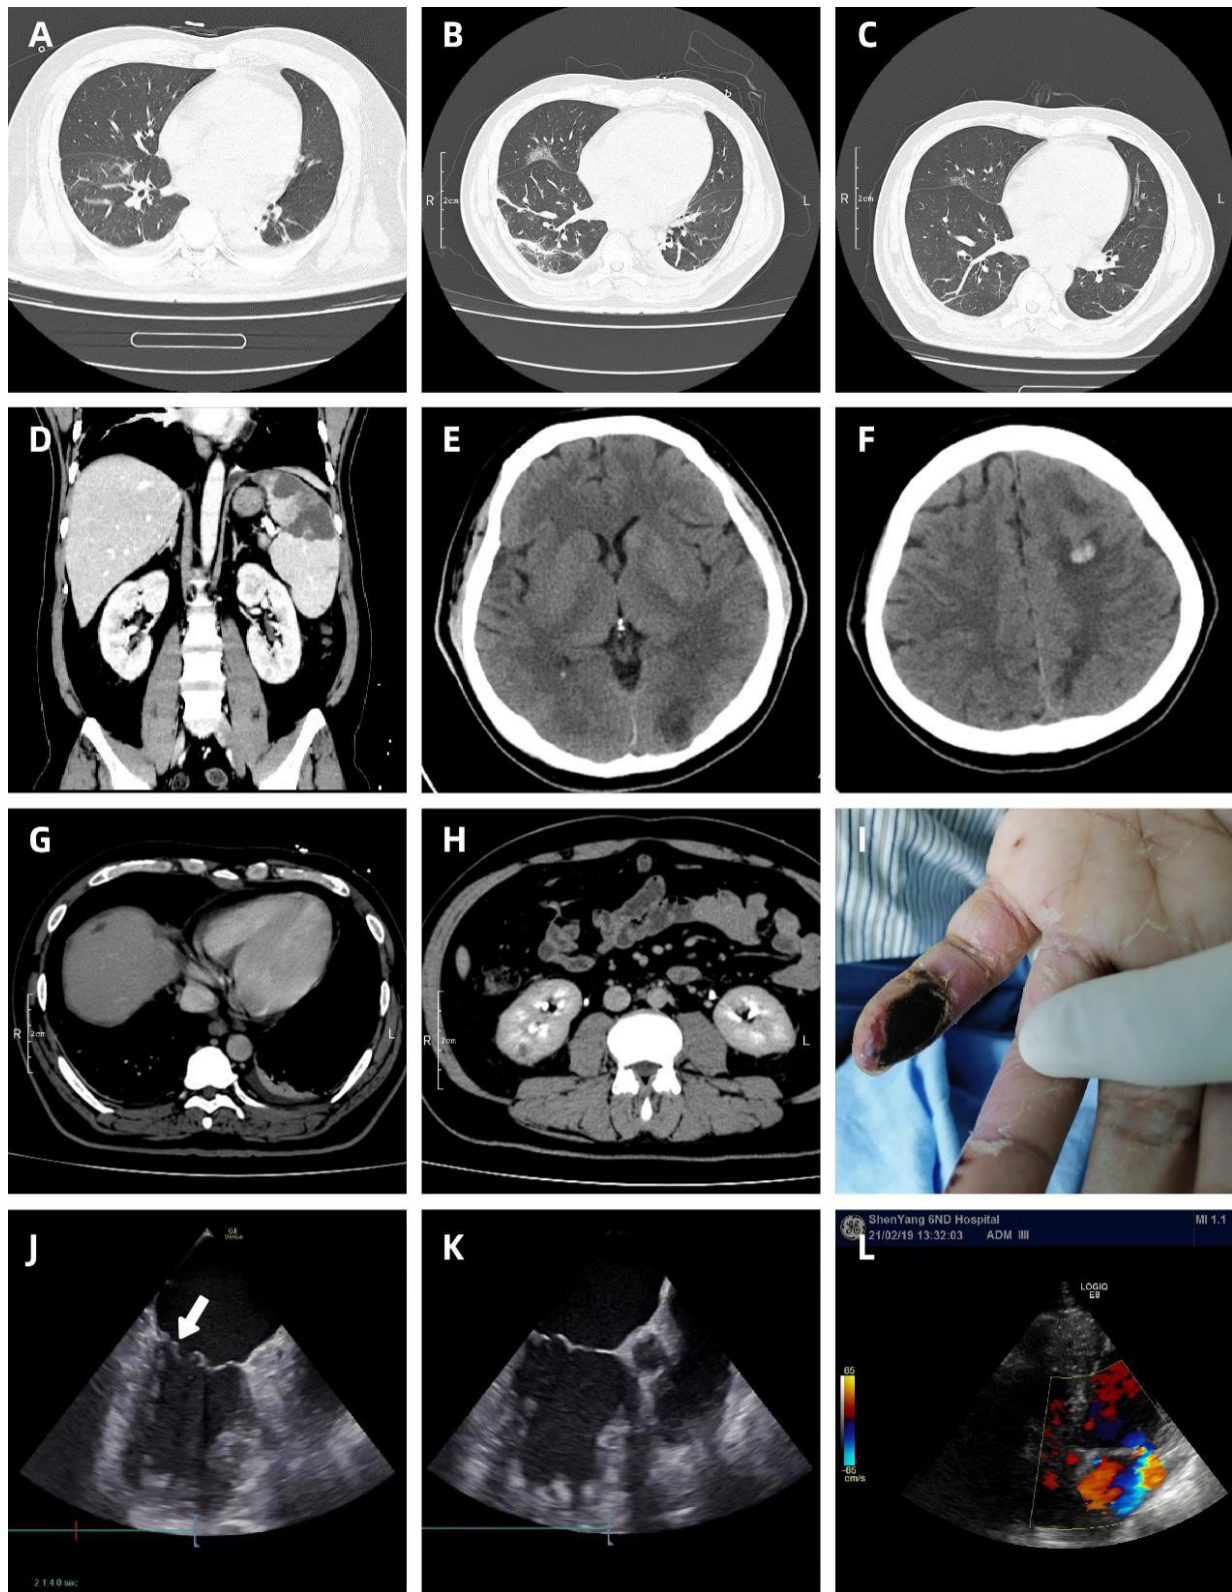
CT image. (A,B,C) The ground glass opacity of both lungs increased from a small amount to a patchy one with thickened blood vessels, and then to the inflammatory lesions. (D) Multiple splenic infarcts with the maximum diameter of 5.1 cm×3.6 cm and the tip pointed to splenic hilum. (E,F) Left parietal lobe hemorrhage and left occipital lobe infection with peripheral edema. (G) Low density necrosis in liver. (H) Low density small infarct in right kidney. (I) Necrosis of distal pinkie of left hand. Transoesophageal echocardiogram: (J) Vegetations in the heel of the left atrium near the posterior lobe of the mitral valve. (K) Mitral valve prolapse. Transthoracic echocardiogram: (L) Mitral valve regurgitation.
